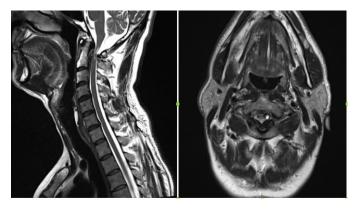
1st patient Pre-operative MRI MRI: Magnetic resonance imaging
